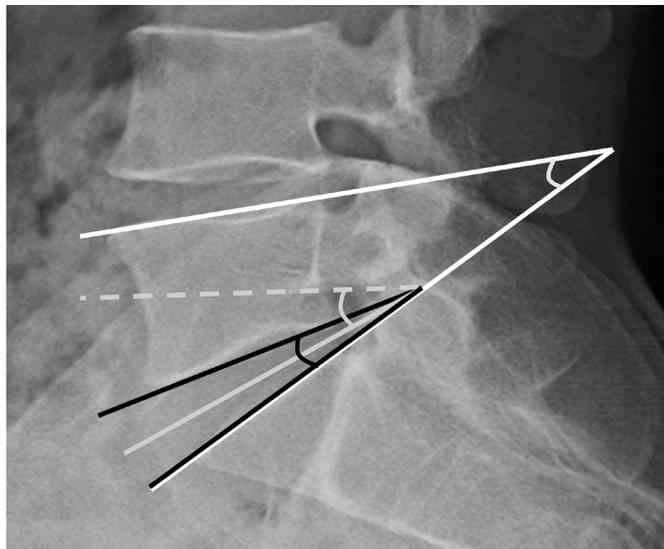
Overview of the radiographic parameters. Disc angle (DA): angle between the L5 lower endplate and the S1 upper endplate (black line). Disc slope angle (DSA): angle between the horizontal line and the line connecting the midpoint between the anterior and posterior of disc spaces (gray line). Segmental lordotic angle (SLA): angle between the L5 upper endplate and the S1 upper endplate (white line).
